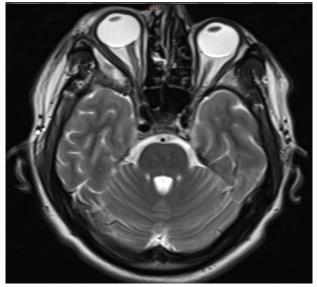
Follow-up with MRI showed no residual or recurrent cyst at six months follow up.
